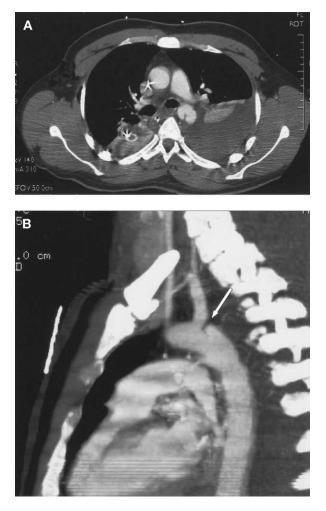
A, Computed tomography scan shows acute contained rupture of aortic isthmus. B, Same patient as in A. Two-dimensional computed tomography scan shows a pseudoaneurysm just distal to the left subclavian artery. Note short proximal neck (*arrow*). Partial coverage of the subclavian artery was mandatory to prevent a proximal type I endoleak.
